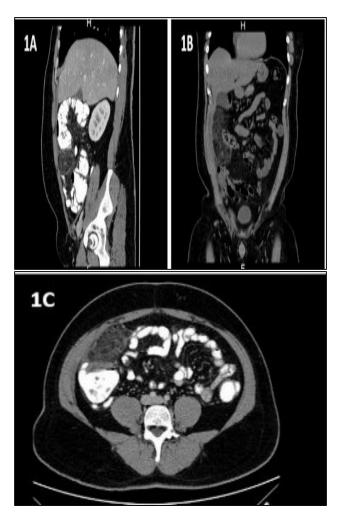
(A-C): A sagittal section of an abdominal CT after injection of contrast, showing a fatty mass in between the ascending colon and anterior abdominal wall, classical whirl sign noted. A coronal section of plain abdominal CT, showing the increased attenuation of fat anterior to the ascending colon. An axial section of abdominal CT after injection of contrast, whirl sign noted anterior to ascending colon.
